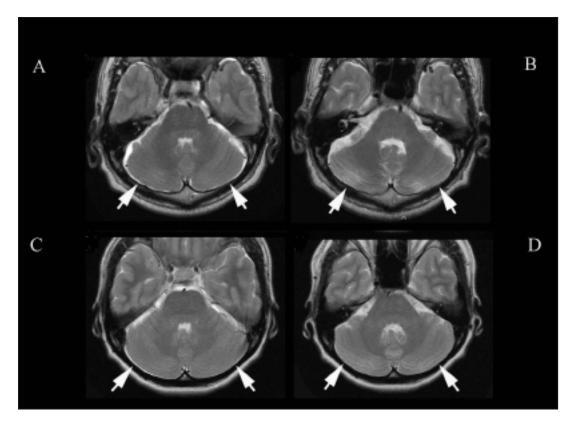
Axial T2-weighted (TR/TE=3500/104) magnetic resonance images without enhancement demonstrating subdural fluid collections (arrows) in the posterior fossa (A,C) which disappeared after treatment (B, D).
